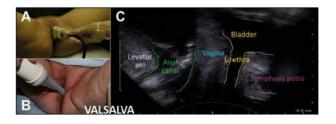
Transperineal/translabial 2D ultrasound with an abdominal transducer (A). Transintroital ultrasound with a vaginal transducer placed in the introitus (B). Image obtained in the medial sagittal plane (C).
